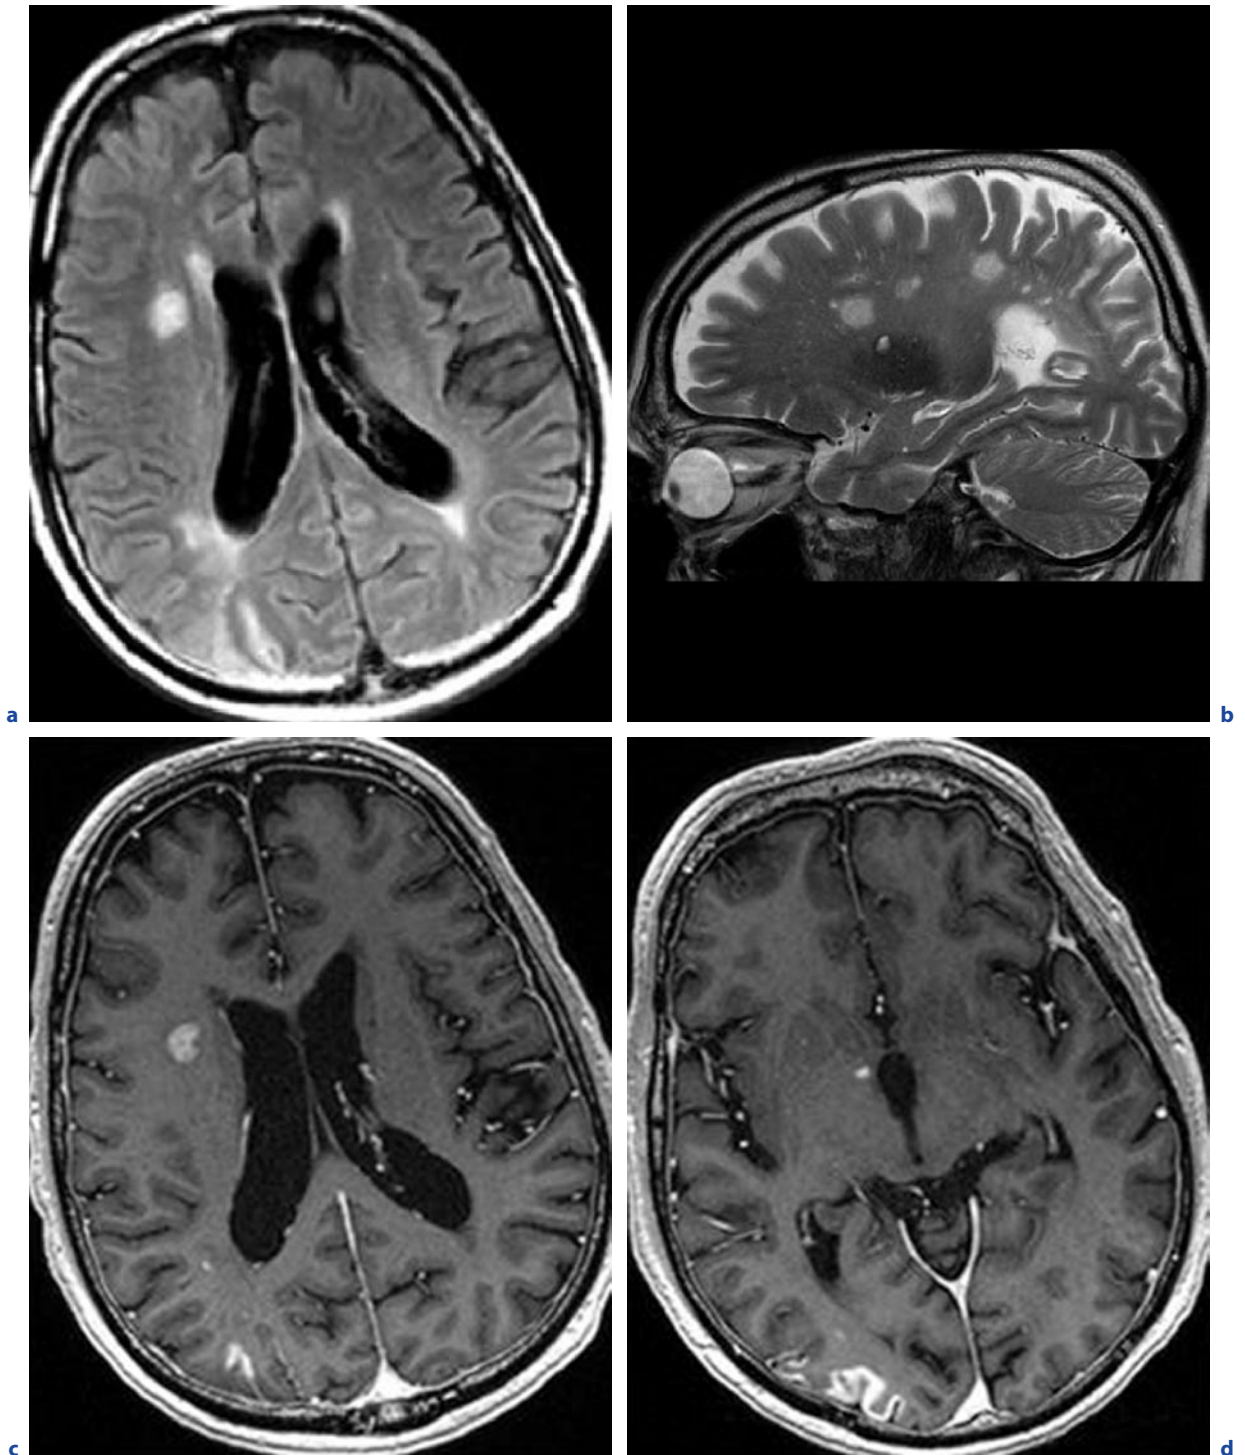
Panarteritis nodosa (PAN). A 65-year-old man with loss of vigilance and intermittent hemiparesis of the left side. Biopsy of the cerebellum and meninges yielded pathological features compatible with those of cerebral vasculitis. He died 3 months after hospital admission. a Axial FLAIR image. b Sagittal T2-weighted image. c,d Axial T1-weighted images after contrast administration. e Coronal T1-weighted image after contrast administration. Irregular subcortical and cortical
